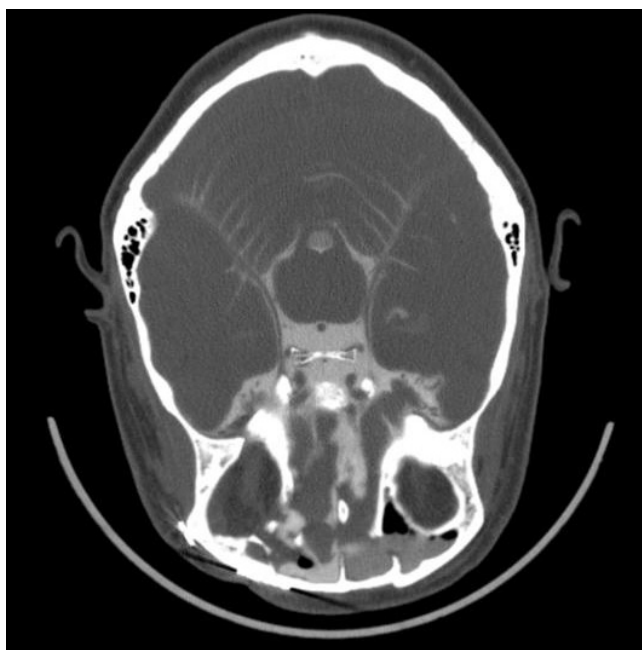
An axial CT cisternography image
